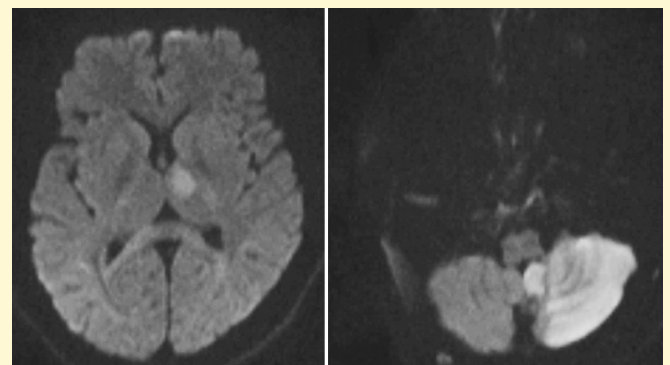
DWI axial images showing acute infarcts in left PICA territory and left thalamus.
